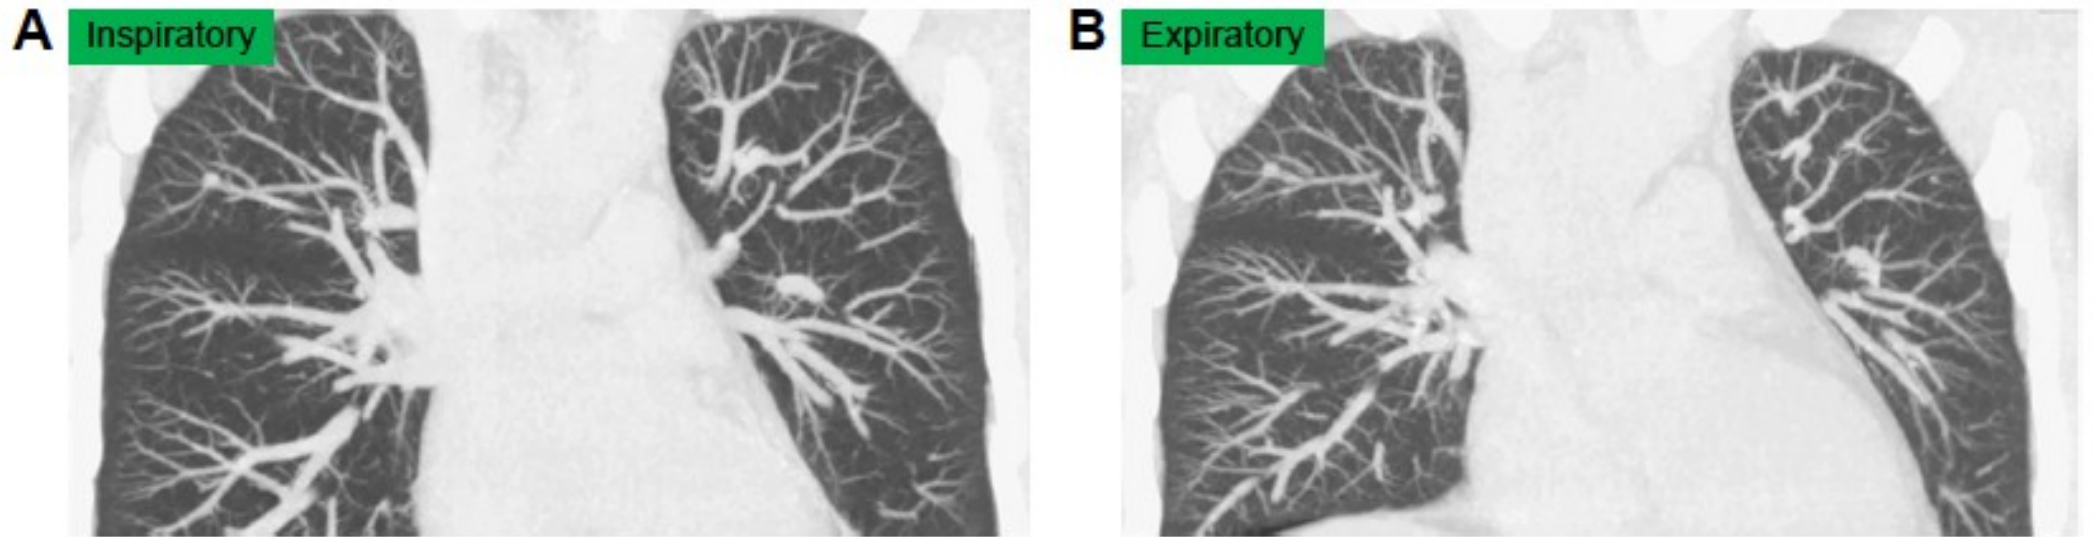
A 39-year-old male current smoker without COPD underwent dynamic-ventilation CT for preoperative analysis of parietal pleural adhesion caused by a benign rib tumor.
